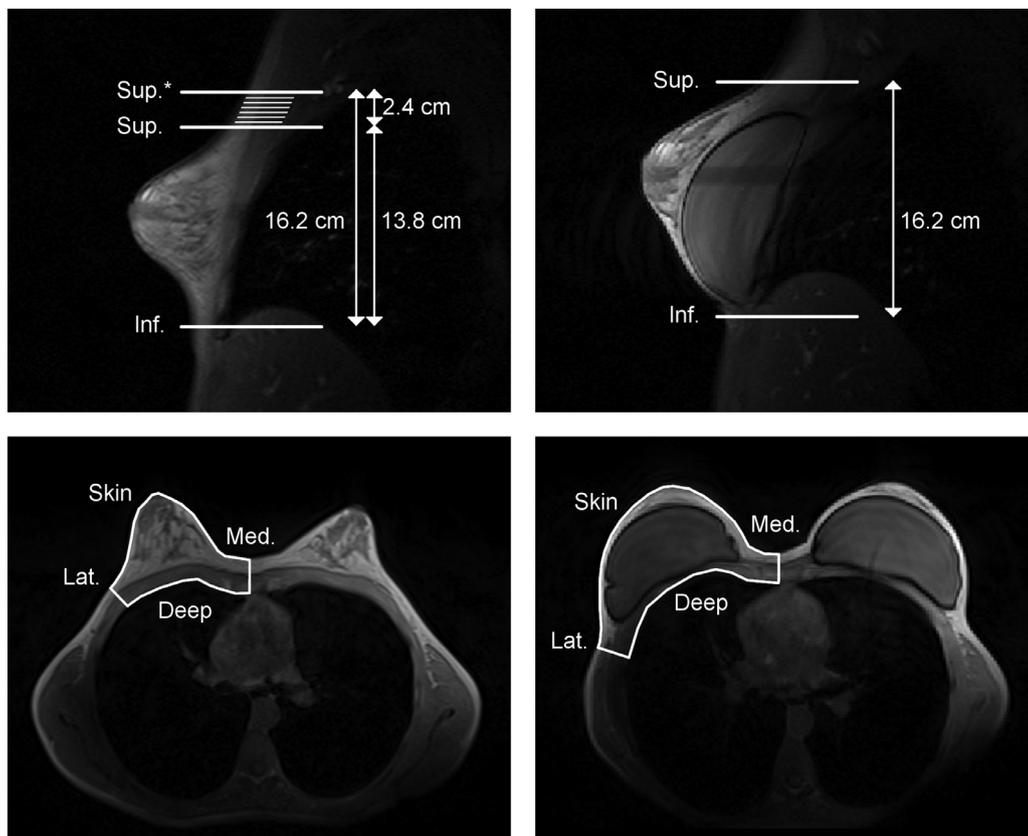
Sagittal and transverse views of the preoperative (left) and postoperative MRI examinations (right) of a patient with breast implants. Sup.* indicates the adjusted cranial border of the preoperative breast, and the hatched area represents the extra tissue added to obtain an equal number of slices on the two examinations. Sup.: superior; Inf.: inferior; Lat.: lateral; Med.: medial.
